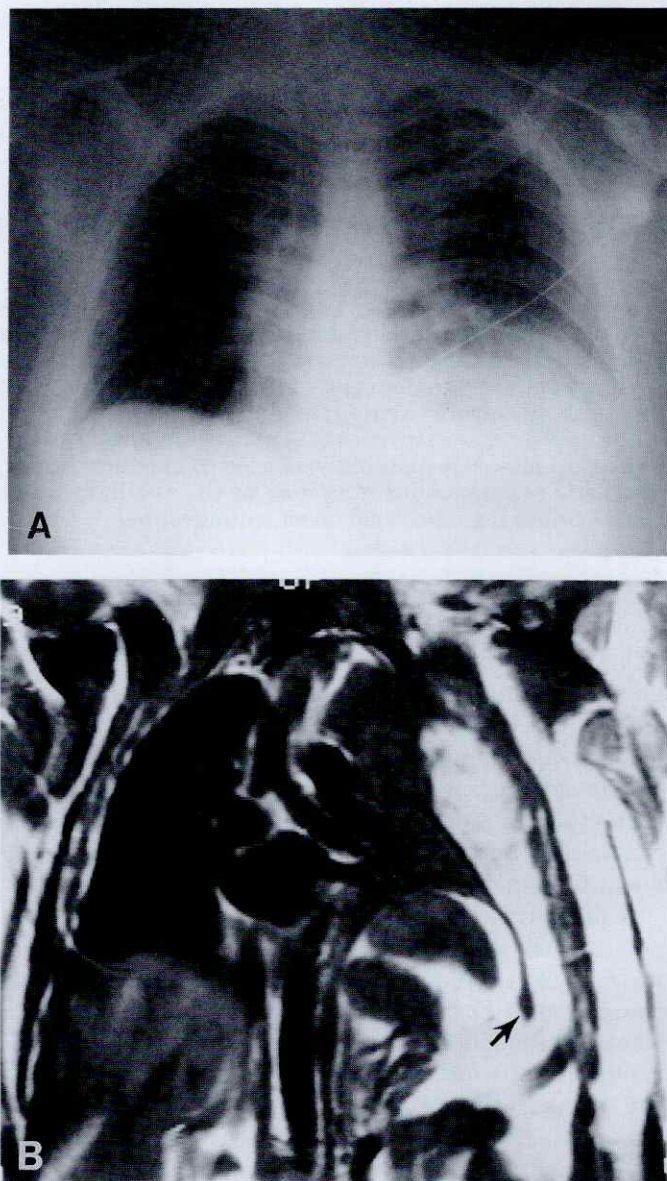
Magnetic resonance images of diaphragmatic rupture: (A) The admission x-ray film of a 29-year-old man after a motor vehicle crash showed a poorly defined and apparently elevated left hemidiaphragm with evidence of some mediastinal shift. Numerous left posterior rib fractures are evident. The study was regarded as suggestive of a left hemidiaphragm injury. (B) A coronal T₁-weighted MRI revealed avulsion of the left hemidiaphragm from the chest wall (arrow), herniation of omental fat (bright tissue) into the left hemithorax, and atelectasis of the left lung. (Reprinted with permission from Gelman R, Mirvis SE, Gens R: Diaphragmatic rupture due to blunt chest trauma: Sensitivity of plain chest radiographs. *AJR* 156:51, 1991.)
